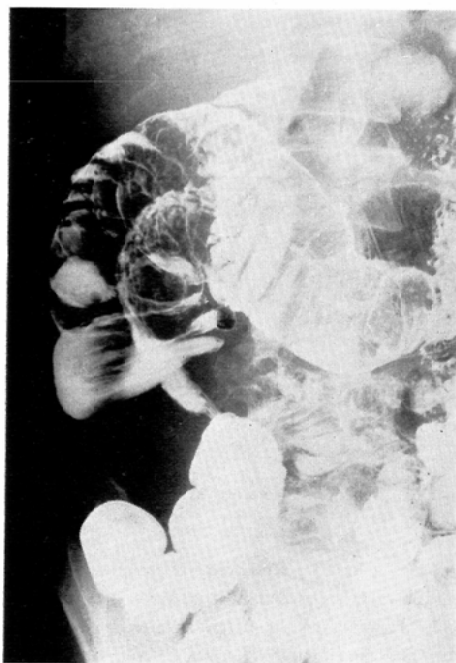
Case 3. Double contrast roentgenogram by aeration through the anal tube at the examination of the colon after a barium meal. The state of intussusception is clearly observable.
